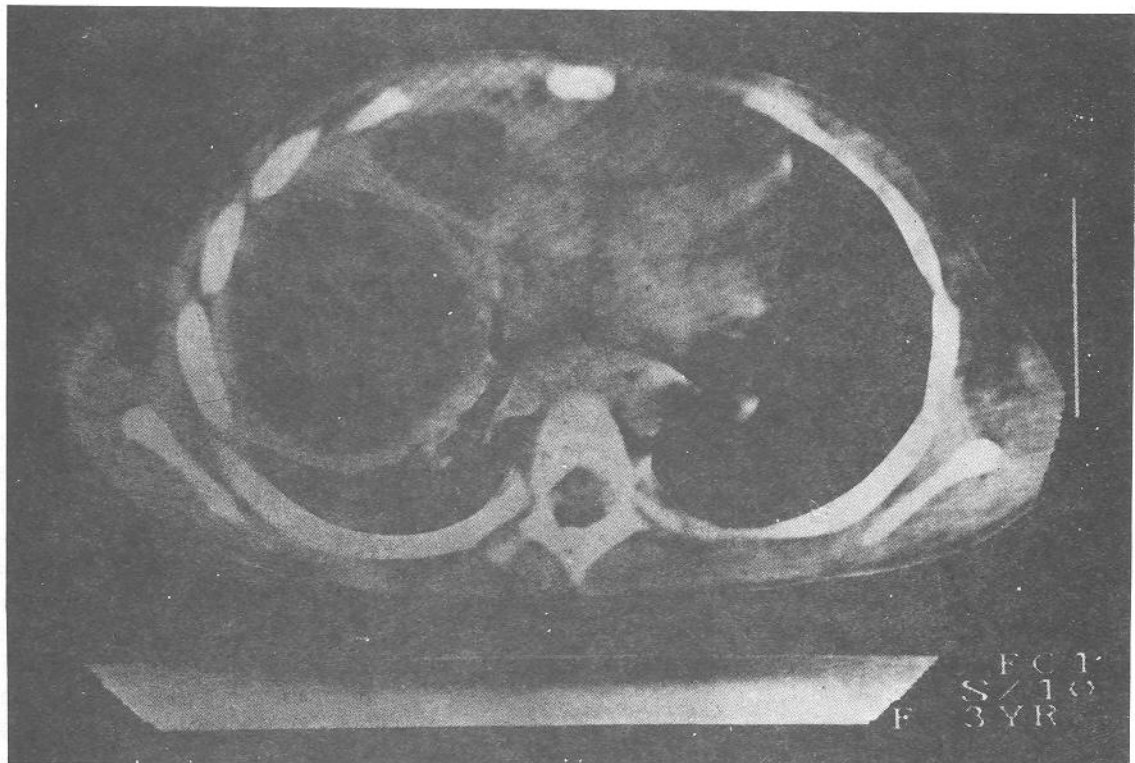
Computed tomography of the chest shows a multiloculated gas-containing abscess occupying the entire right middle lobe.
